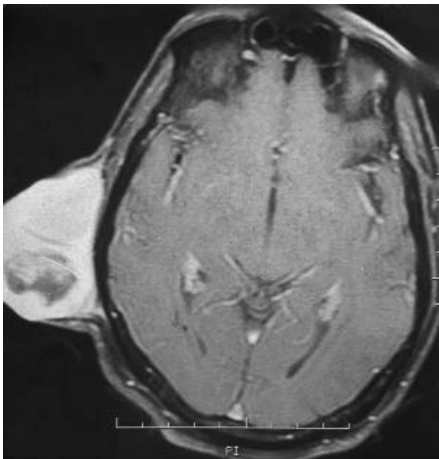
Magnetic resonance imaging showing a soft tissue density mass in the right parietal region
